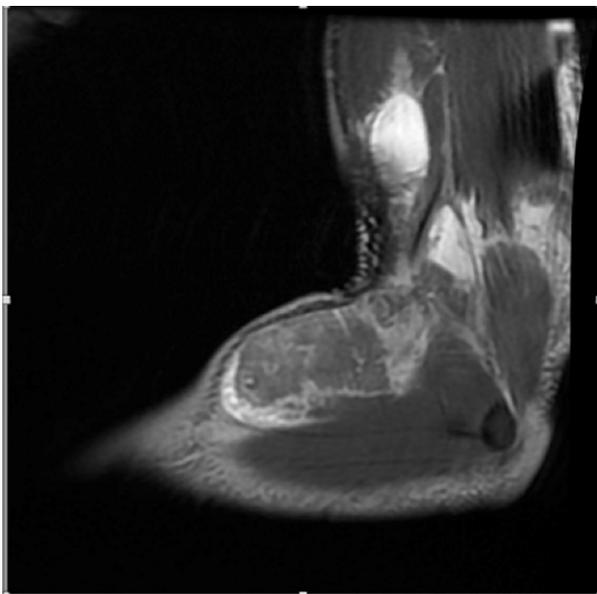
T2-weighted magnetic resonance image showing increased signal and segmental defect of biceps brachii muscle with incarceration of distal segment in forearm.
